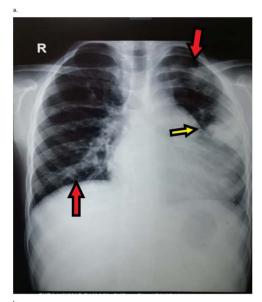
Chest x-ray of the child at the time of presentation (a) showing various bilateral nodular densities (red arrows), along with subpleural wedge shaped opacity on left lung (yellow arrow). They were significantly reduced at the time of discharge (circle) (b).
